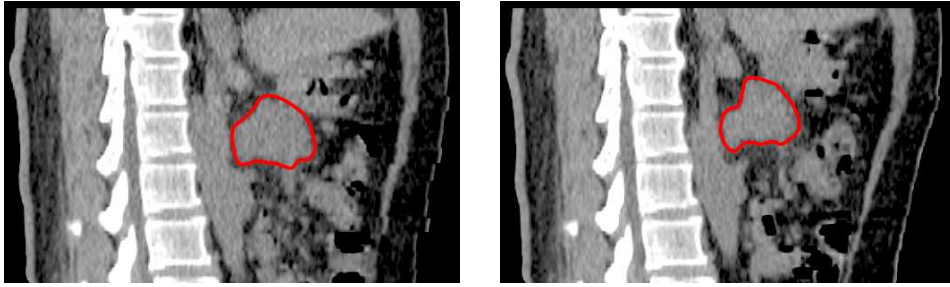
Pancreatic tumor at the end of inspiration phase (left) and end of expiration phase (right) in a series of CT scan images. The center of mass of the tumor moves up and down due to the breathing motion and the tumor shape also changes following that motion.²
